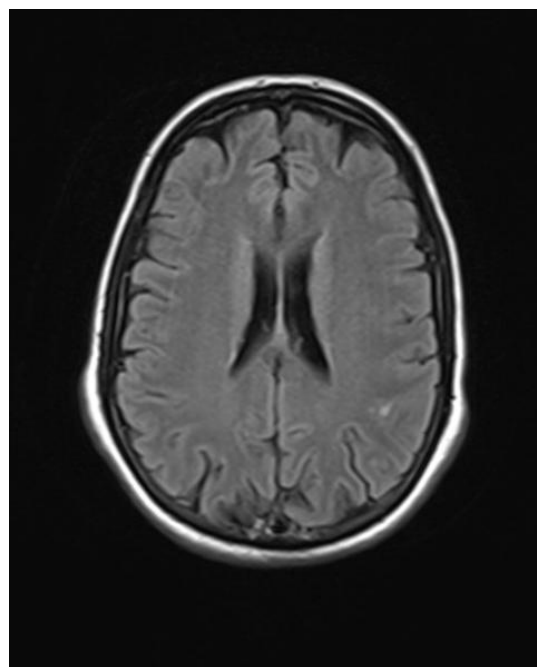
Two hyperintense lesions were found on FLAIR sequences on corticomedullary junction of parietal lobe
